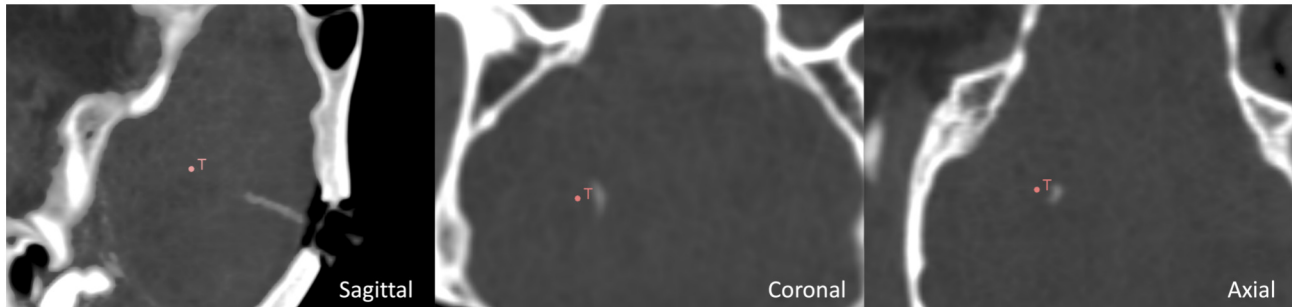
Ex-vivo post CT image. T define the target point, while the white shadow is the catheter
